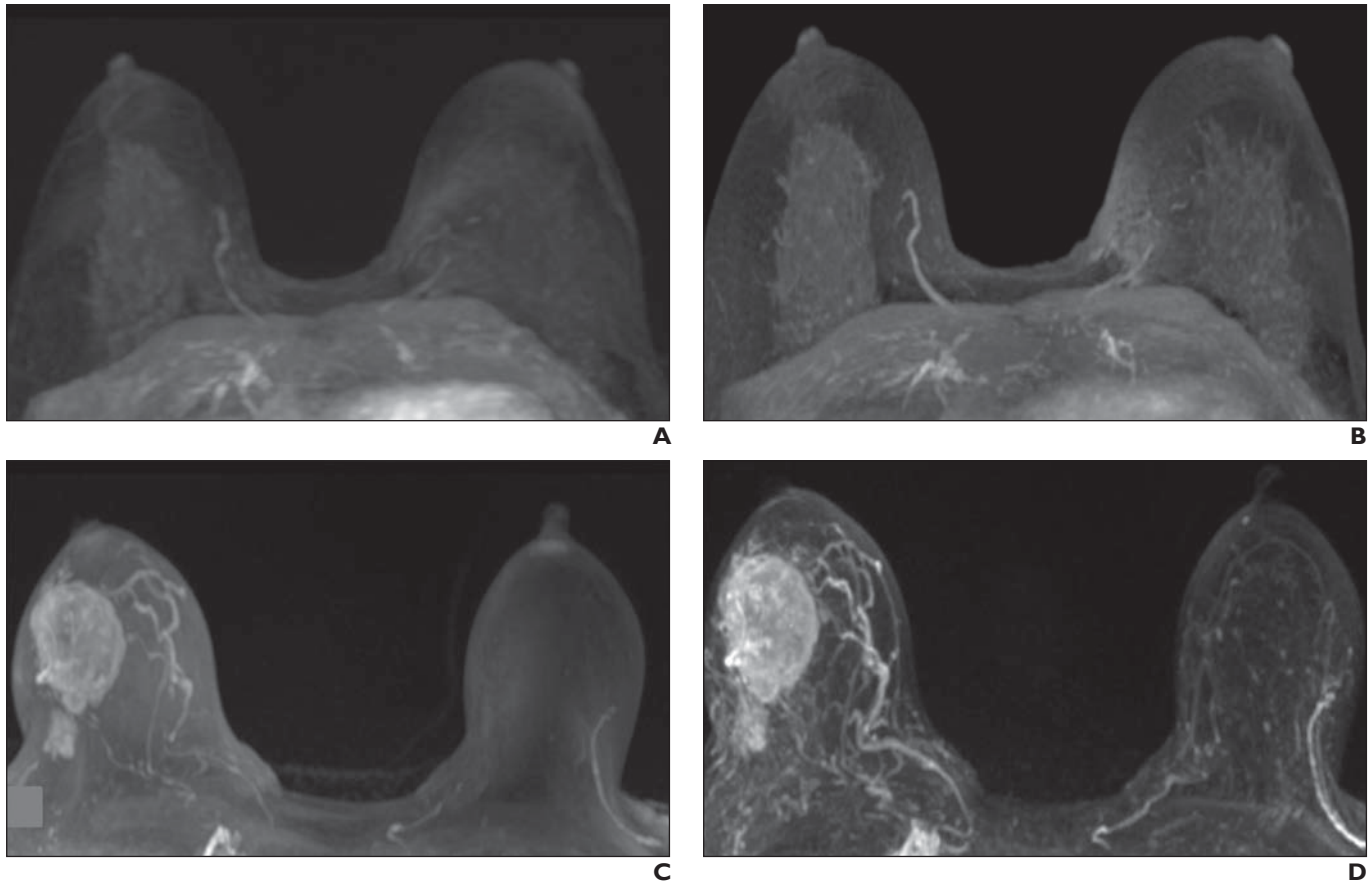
Maximum-intensity-projection (MIP) image analysis built on subtracted images of ultrafast sequence and subtracted images of conventional dynamic contrast-enhanced (DCE)-MRI.
